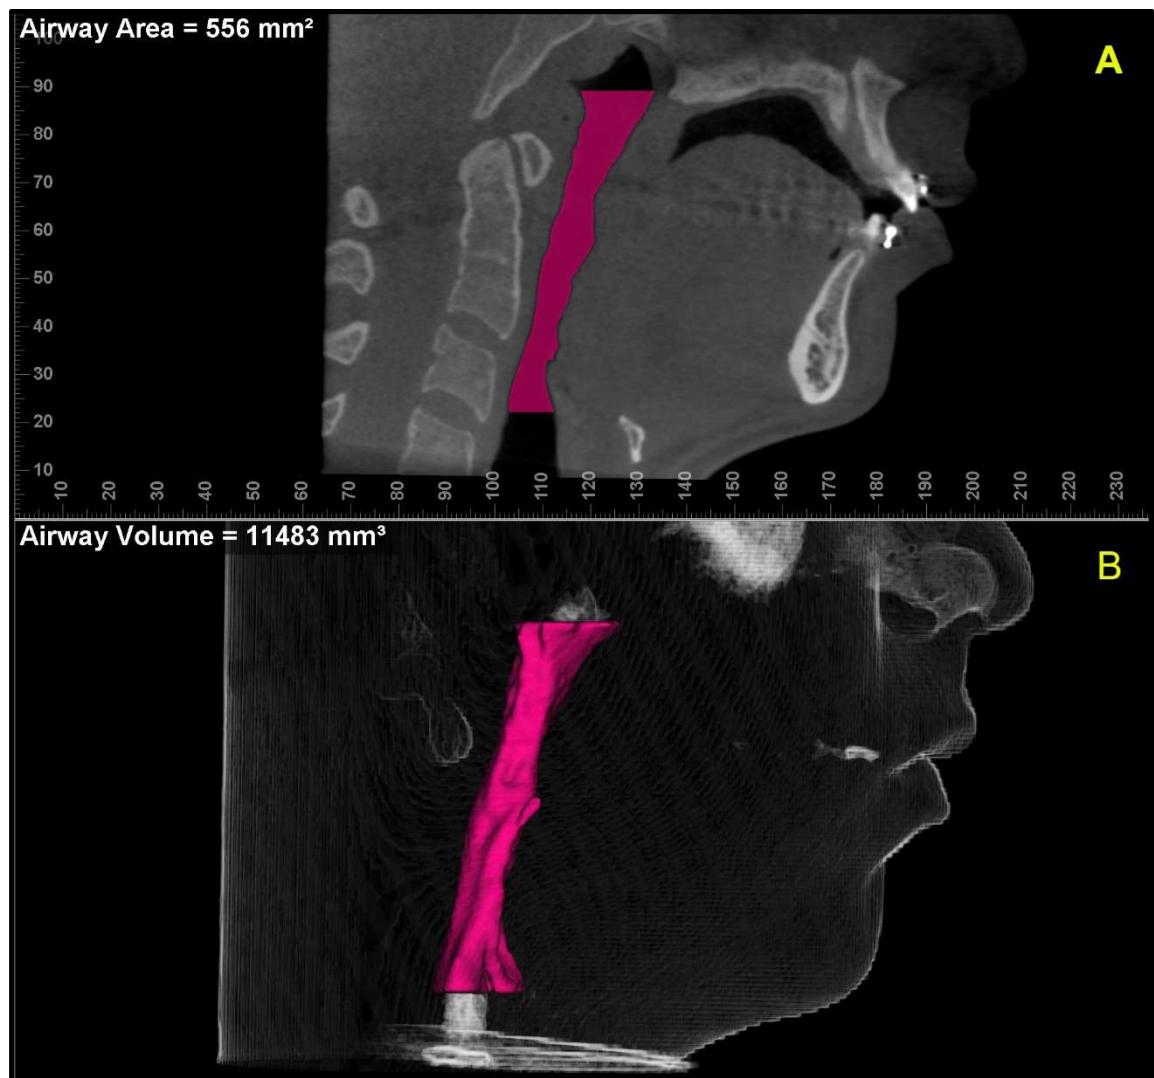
Oropharynx delimited in the CBCT: (A) Sagittal reconstruction indicating the medial sagittal area (MSA); (B) Three-dimensional reconstruction indicating the volume of oropharynx.
